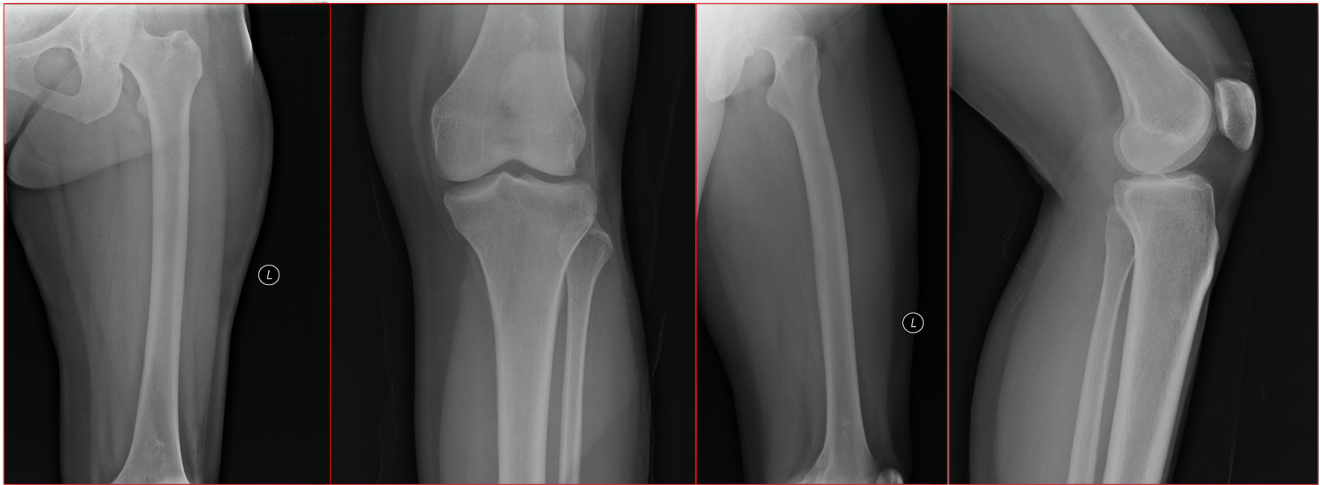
Preoperative AP and lateral x-rays of the patient with LGC in left distal femur
